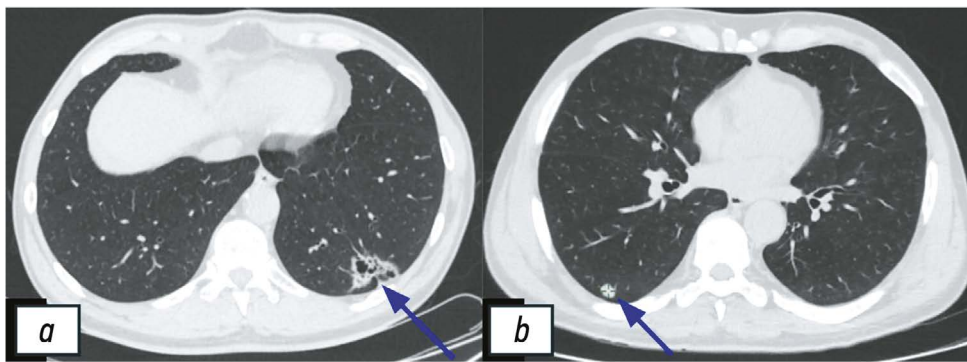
Chest computed tomography findings in patients with confirmed lung cancer (blue arrows). *a*, cystic and solid mass in the left lung (stage Ia); *b*, solid mass in the right lung (stage Ib).
